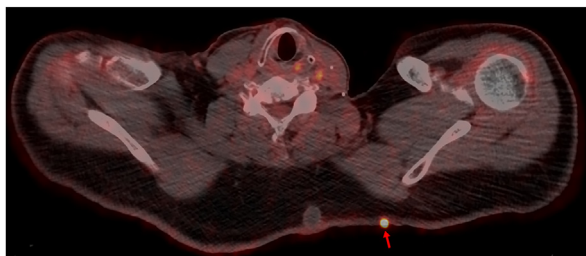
Axial fused positron emission tomography-computed tomography (PET-CT) demonstrates a hypermetabolic cutaneous focus along the left upper back with SUV-max measuring 7.98 (*arrow*). A photopenic epidermal inclusion cyst is incidentally noted towards the *midline*. There was otherwise no metabolic evidence for metastatic disease.
